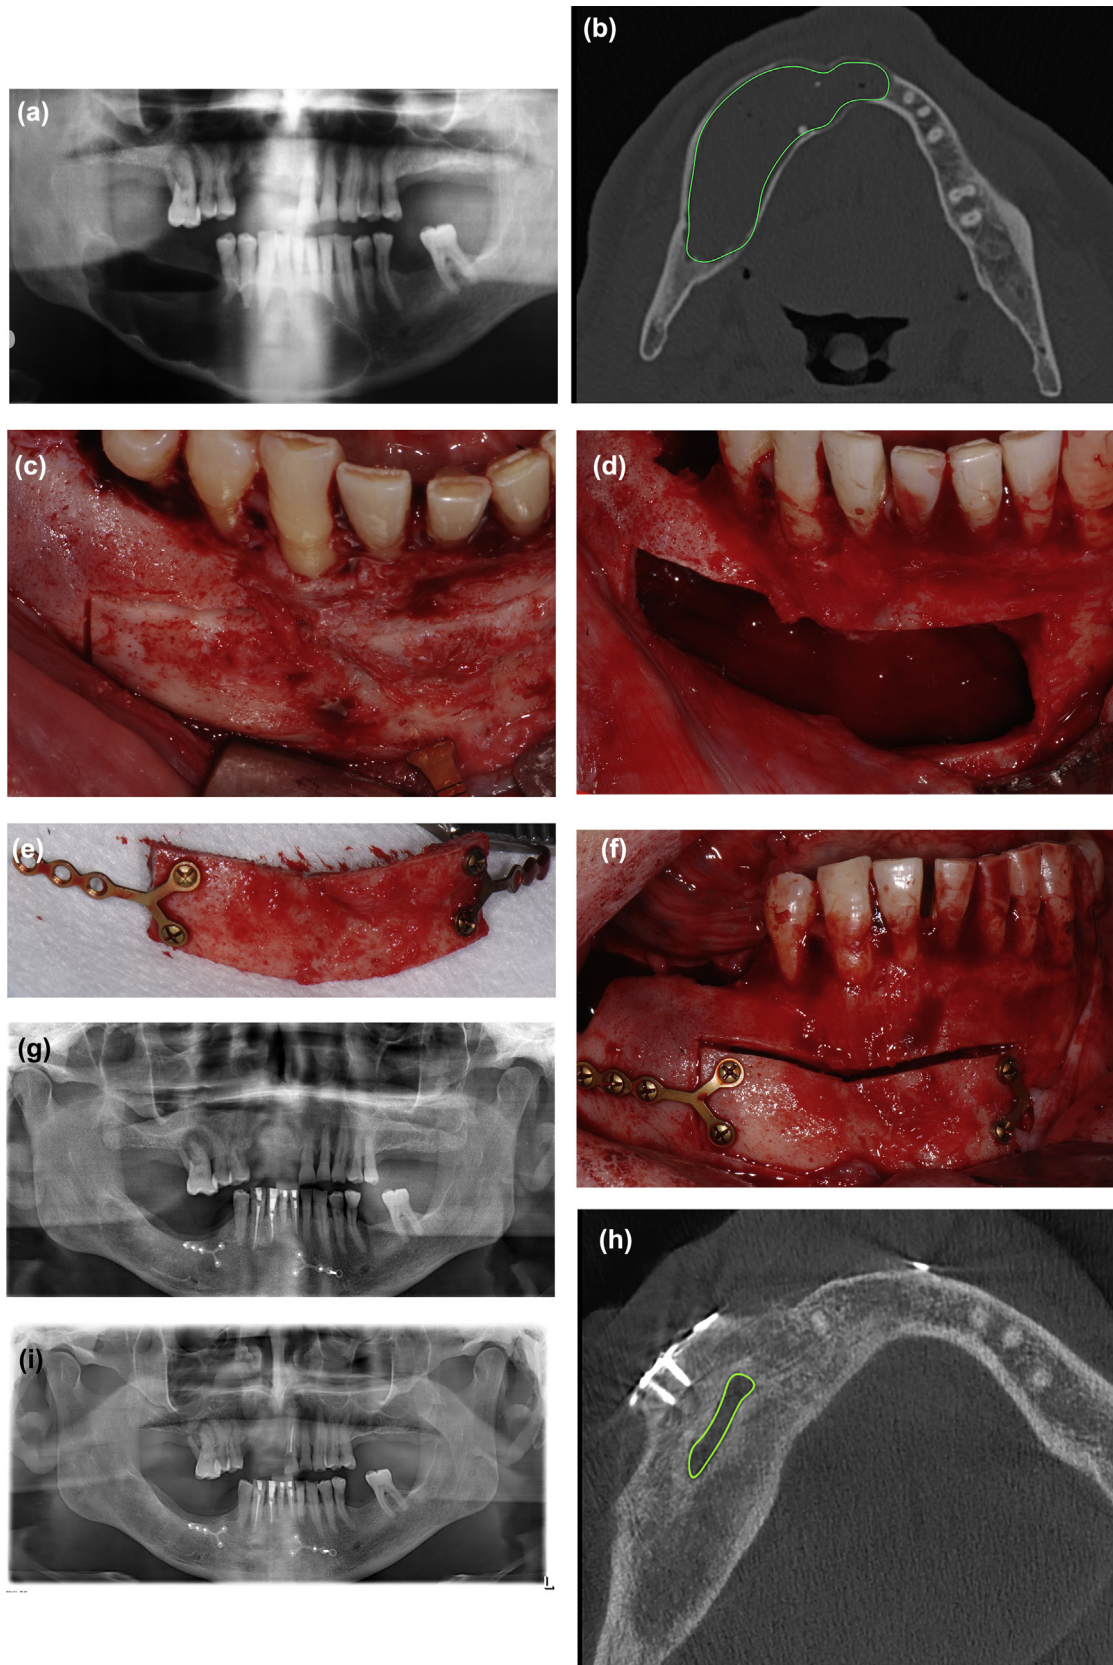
Images for case patient 4. (a) Preoperative panoramic radiograph showing a large radiolucent lesion involving the right mandibular body and symphysis. Among the teeth affected by the lesion, teeth 41 and 44 responded to both electric and cold pulp vitality tests. (b) Preoperative CT scan, axial view. (c) Mandibular buccal bone lid fashioned using piezosurgery (Piezosurgery insert OT7, bottom right), prior to its detachment. (d) Removal of the bone lid, providing access to the cystic lesion. Tooth 45 was extracted during the surgical procedure. (e) Bone lid
